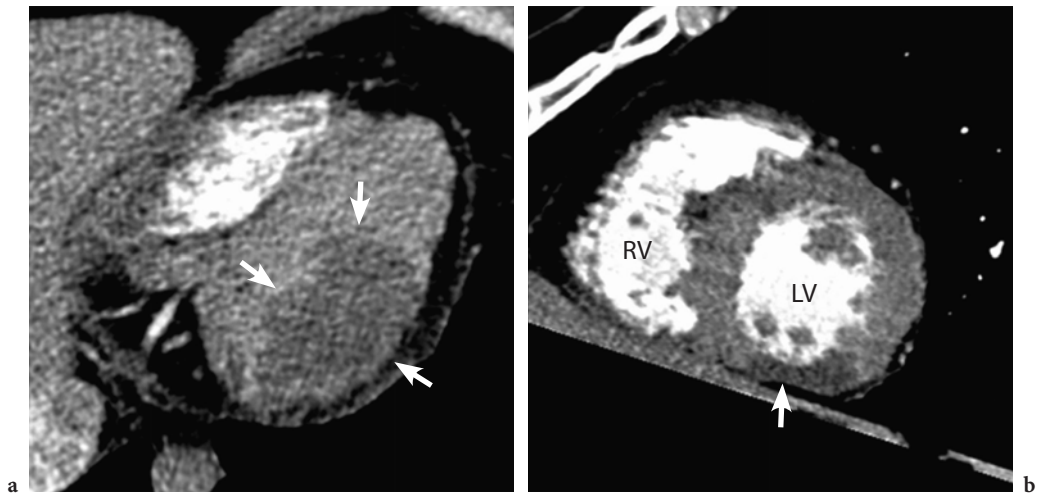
16-slice CT examination of a 52 year-old male patient. The original axial image of the inferior left ventricular wall reveals a recent infarction (<30 days), depicted as a moderately circumscribed area with CT densities of 60-80 HU (a, arrows). In the same patient, the multi-planar reformation (MPR) in a short axis view clearly depicts the extent of the inferior myocardial infarction and shows mild wall thinning in (b, arrow)
